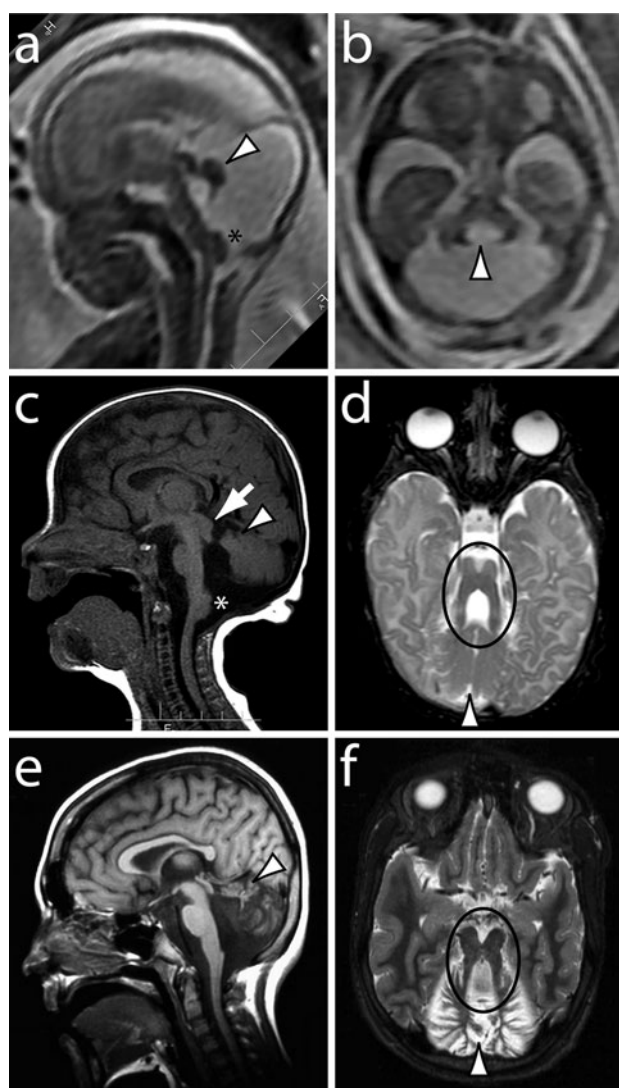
MRI findings in Subjects 2, 4 and 5. a, b Subject 2 at 21 wg; c, d Subject 4 at 5 weeks; e, f Subject 5 at 13 years. All subjects have vermis hypoplasia (arrowheads) on sagittal (a, c, e) and axial (b, d, f) views. The roof of the 4th ventricle is more horizontally oriented than normal, indicating horizontal orientation of the SCPs. The hemispheres impinge on the midline in Subject 4, making it difficult to see the vermis hypoplasia on the sagittal view (arrowhead in c). The molar tooth sign (long thick superior cerebellar peduncles and deep interpeduncular fossa) is apparent on axial views in Subjects 4 and 5 (circles in d and f, respectively). As expected, thick, horizontally oriented SCPs are not demonstrated on axial views in fetal Subject 2 (b), but are apparent in postnatal Subjects 4 (d) and 5 (f). Abnormal excess tissue is present on the dorsal aspect of the cervicomedullary junction in Subjects 2 and 4 (asterisks in a, c). The posterior fossa is enlarged in Subject 2 (a), and Subject 4 has an abnormally thick and dysplastic tectum (arrow in c). Subject 5 has prominent fluid spaces between the cerebellar folia giving an atrophic appearance (f)
